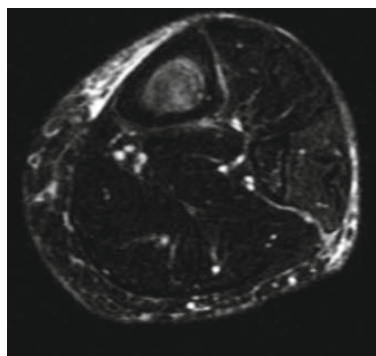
Axial T2-weighted image of an athlete with MTSS showing periosteal edema on the anteromedial side of the tibia.
